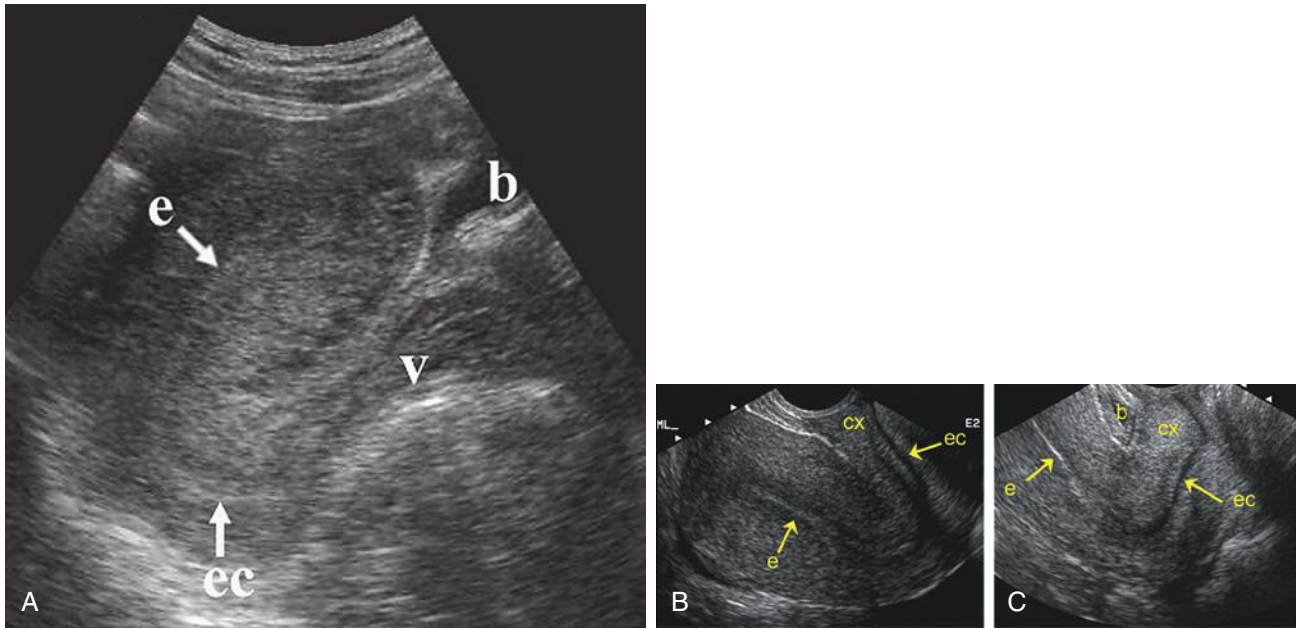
Anteflexed uterus. A, Transabdominal sonogram in the midline sagittal plane through the uterus. The bladder (b) is almost completely empty. B, Transvaginal midsagittal scan of an anteflexed uterus. C, Transvaginal scan of the cervix and lower uterine segment. The bladder (b) is almost empty. The endocervical (ec) and endometrial (e) canals form an angle of approximately 90 degrees in all three images at the level of the internal os. cx, cervix; v, vagina.
